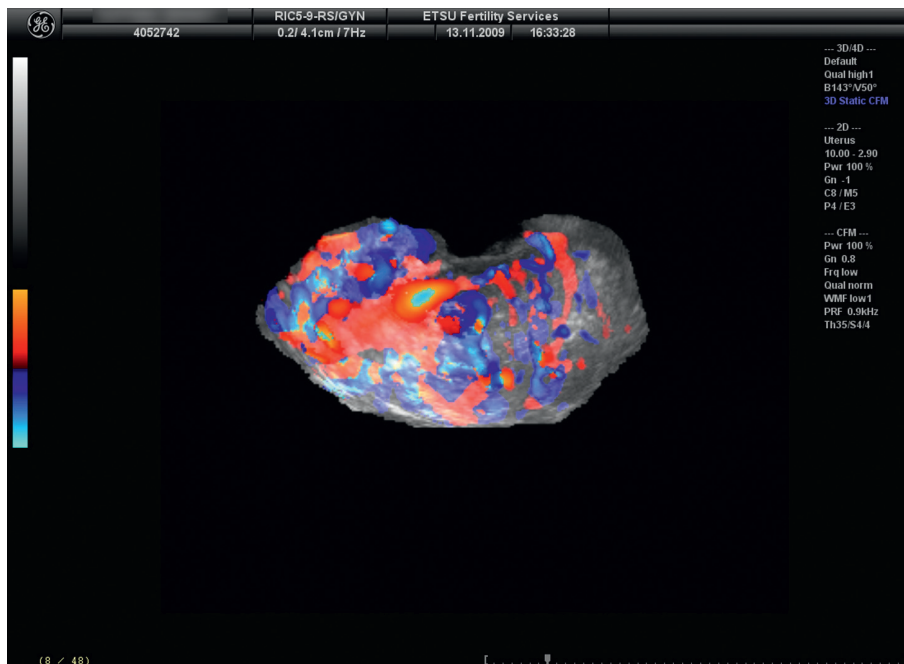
Color Doppler acquisition of ovary showing “beach ball structures, strictures, and loss of tree-like vascularity” [32]. This lesion was a granulosa cell tumor of the ovary.
